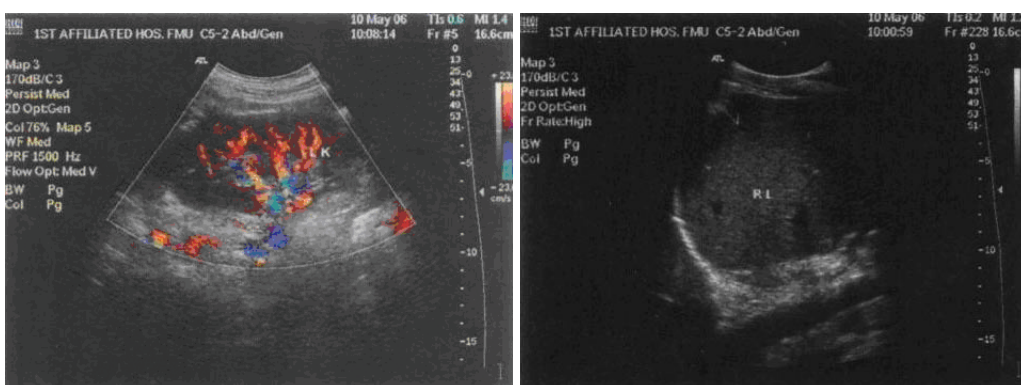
Features of ultrasound examination before operation of the brain metastasis.
